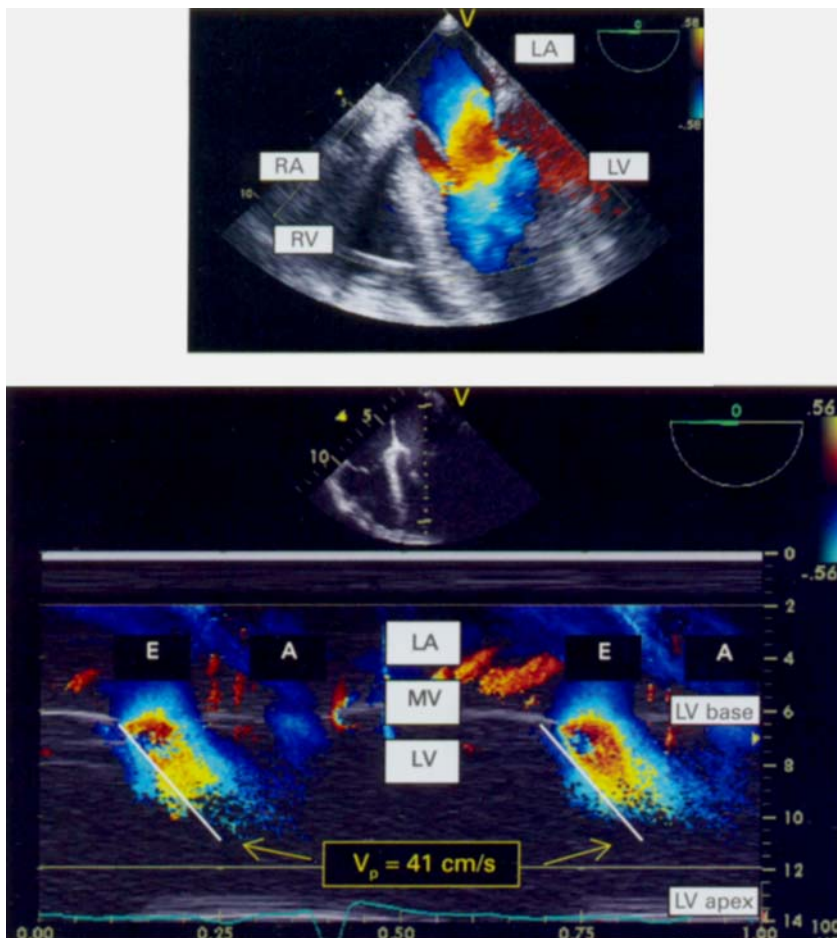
Colour Doppler and colour M-mode Doppler images of the transmitral inflow obtained by transoesophageal echocardiography from a mid-oesophageal four chamber view. On the colour M-mode Doppler tracing the early (E) and atrial contraction (A) waves are shown. Flow propagation velocity (V_p) is given by the slope of the colour wavefront. LA = left atrium, LV = left ventricle, MV = mitral valve, RA = right atrium, RV = right ventricle.
